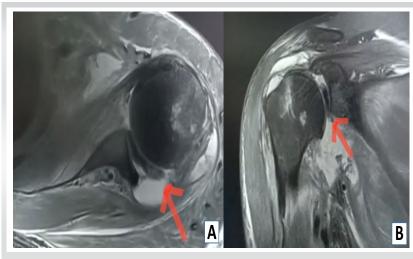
Magnetic resonance imaging shows entrapped capsule (A) axial section, (B) coronal section.
